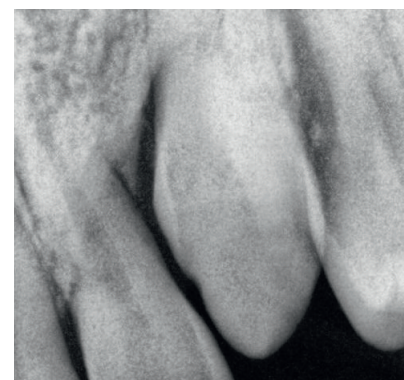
Intraoral X-ray following treatment with Biodentine
